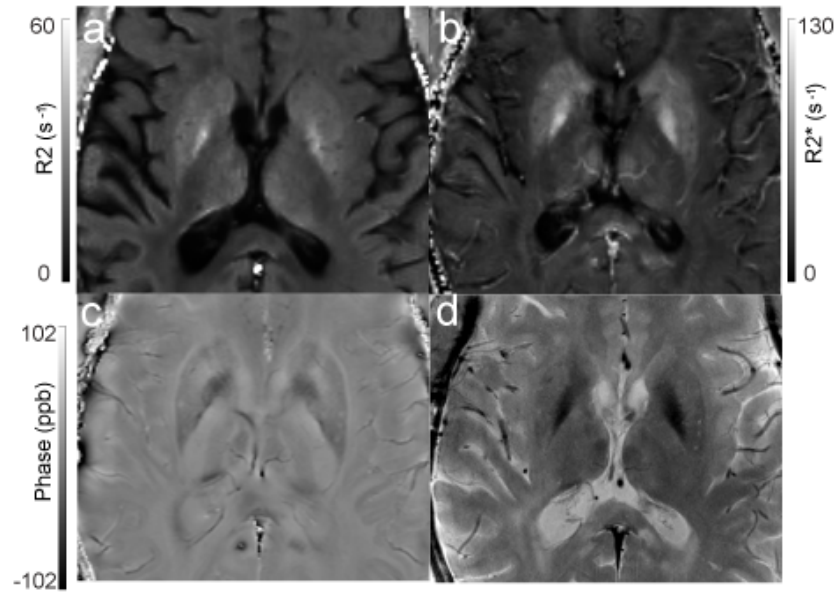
In vivo (a)  $R_2$ , (b)  $R_2^*$ , (c) phase with gradient background removal, and (d)  $T_2$ -weighted fast SE MR images from subject 4. Note that vessels are less pronounced on b and c, acquired in vivo versus postmortem (Fig 4.3). ppb = parts per billion, s = seconds.
